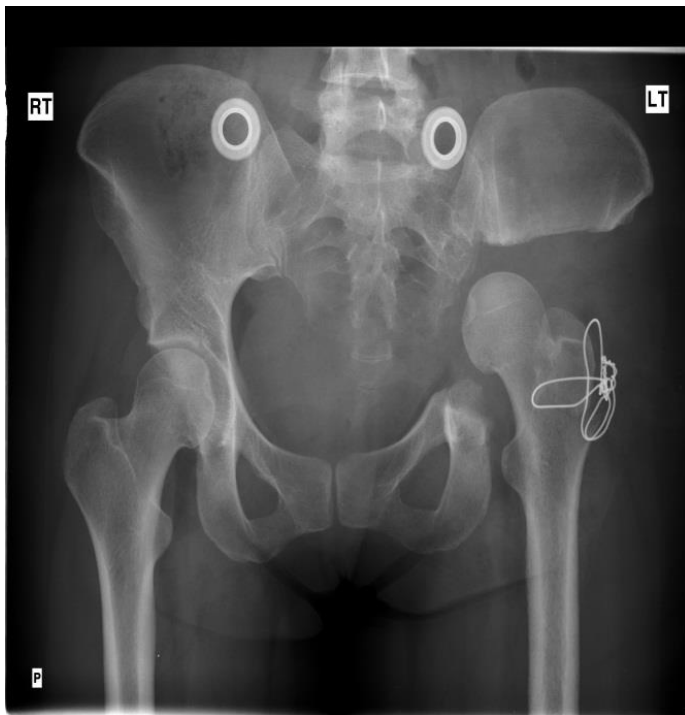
AP radiograph of the pelvis showing a type II resection and a flail hip.
